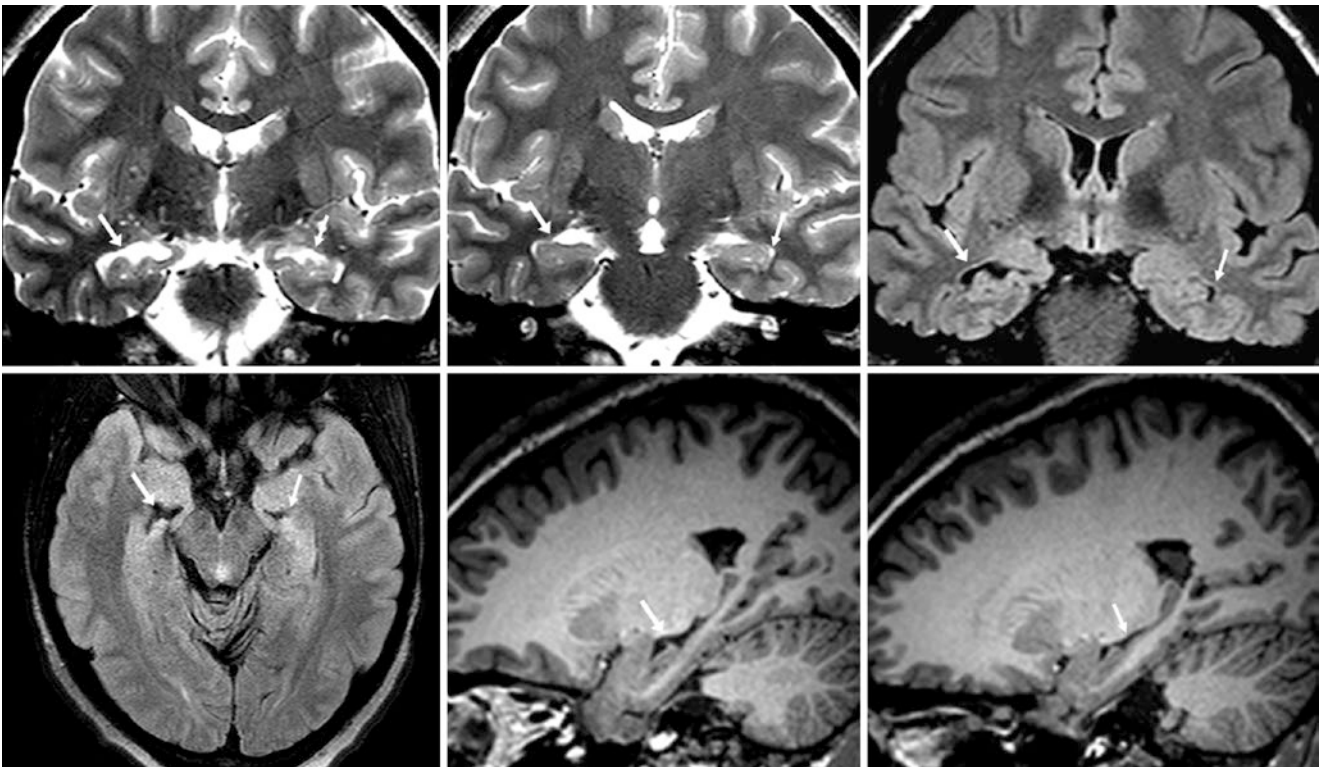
A 21 year old was given a coronal T2WI MRI (*top left, top middle*) that demonstrated prominence of the right temporal horn anteriorly (*arrows*) as compared to the left (*thin arrows*). This is clearly indicated to be within the ventricular system on coronal (*top right*) and axial (*bottom left*) FLAIR images and is therefore shown not to be a cyst. Sagittal T1WIs of the right (*bottom middle*) and left (*bottom right*) sides further depict the temporal horns
